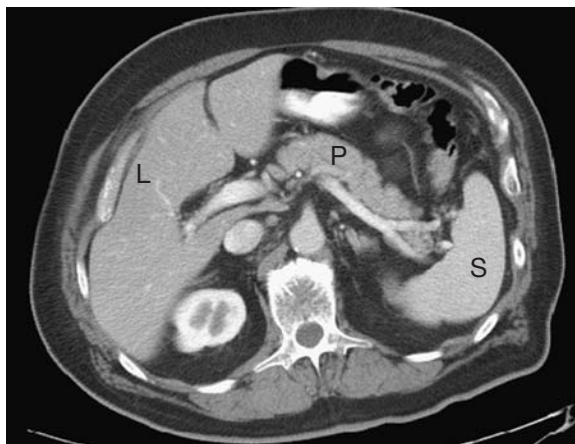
Normal contrast-enhanced computed tomogram of the pancreas. Note that the pancreas (P) has a uniform enhancement intermediate between that of the liver (L) and spleen (S).
